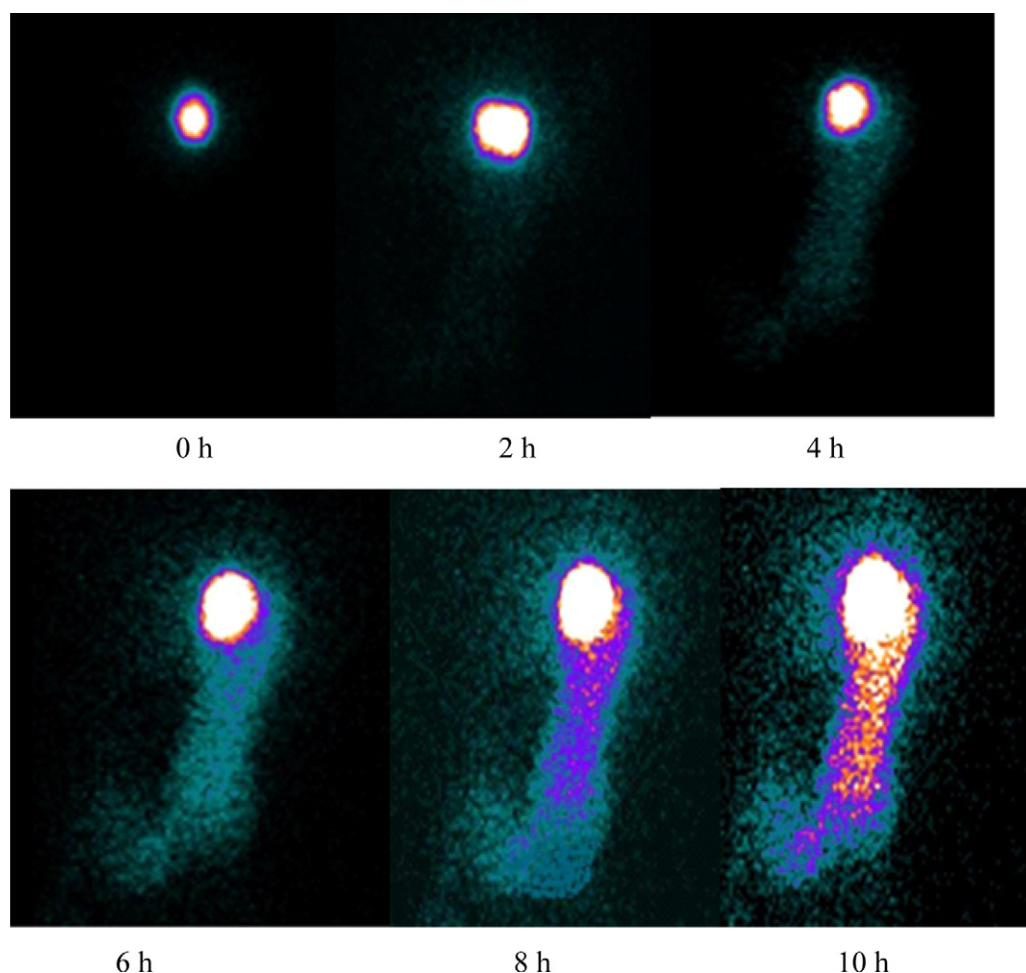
Gamma scintigraphic images of FB in volunteer 2 after 0, 2, 4, 6, 8, 10 h respectively.
